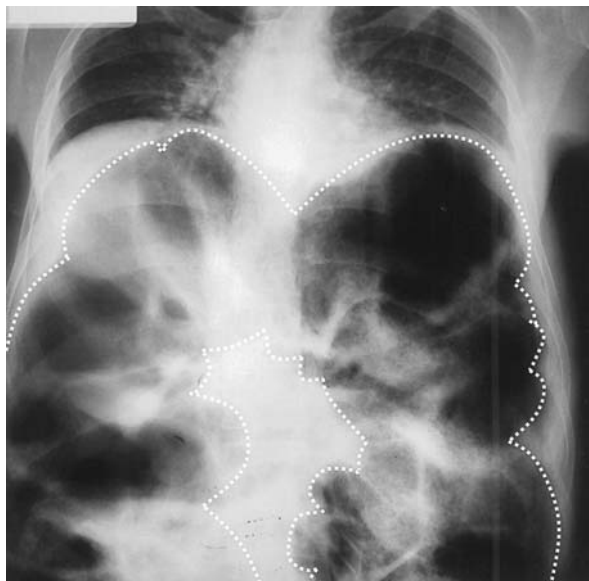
Abdominal X-ray revealed air-fluid levels in the extremely distended intestine
